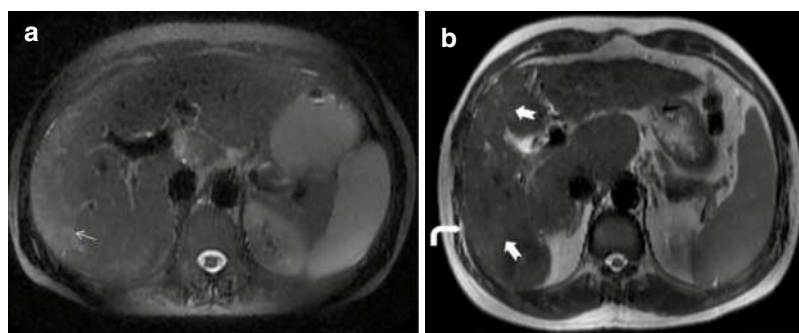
Imaging findings in biopsy-proven cases of AIH. (a): Early inflammation is characterized by patchy reticular hyperintensities in T2-weighted sequences (white arrow) and hepatomegaly. No evidence of surface
